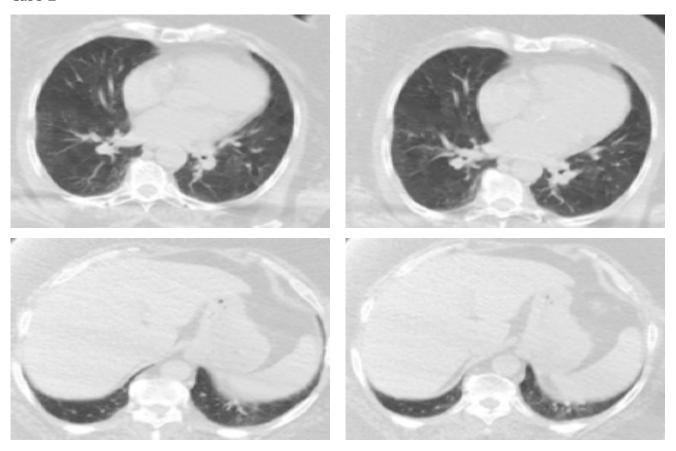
Thoracic CT showed mosaic attenuation in bilateral lungs, subsegmental atelectasis in the left lung lower lobe and several ground-glass density nodules in the lower lobe posterior segment.
